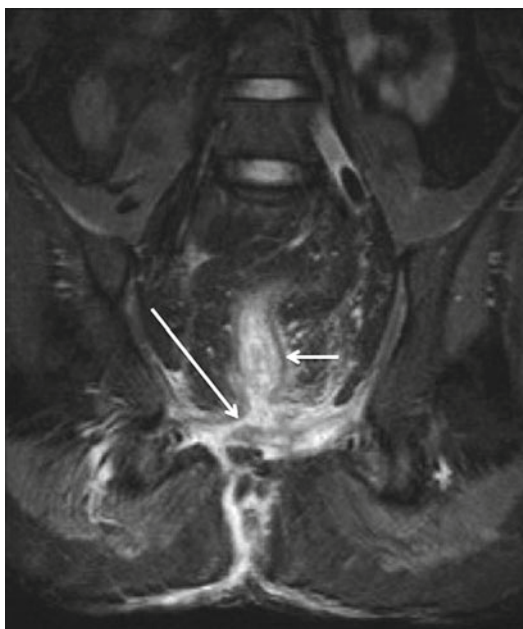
Coronal STIR MRI in a man with an extrasphincteric fistula. Note that the primary fistula track has a rectal opening (*long arrow*) above the level of the levator plates (rectum=*short arrow*)
